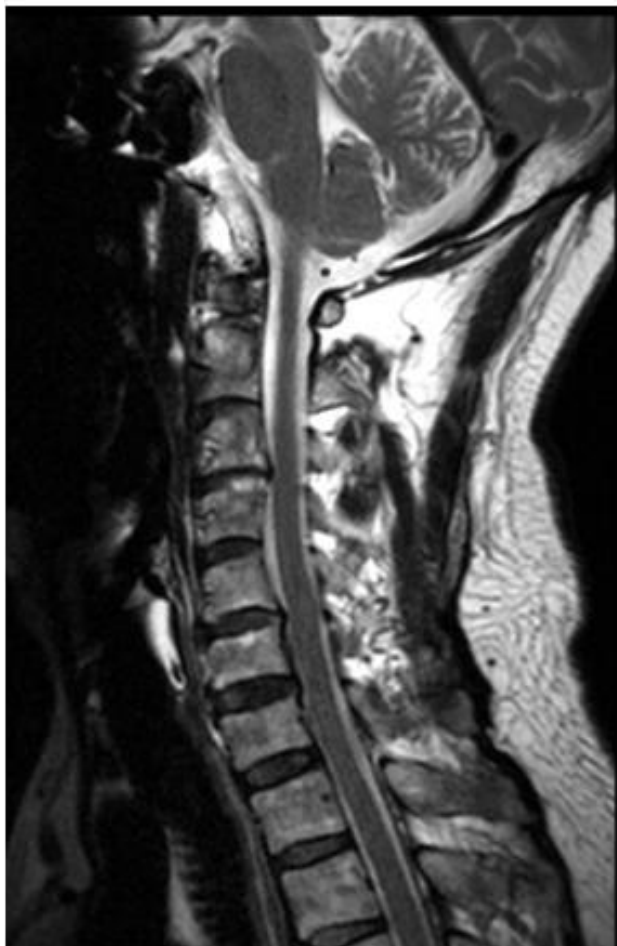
Preoperative MRI. Sagittal T2-Weighted and axial plane showing disc protrusion severely compressing spinal cord at C3/4 level and minimal at C5-6.
